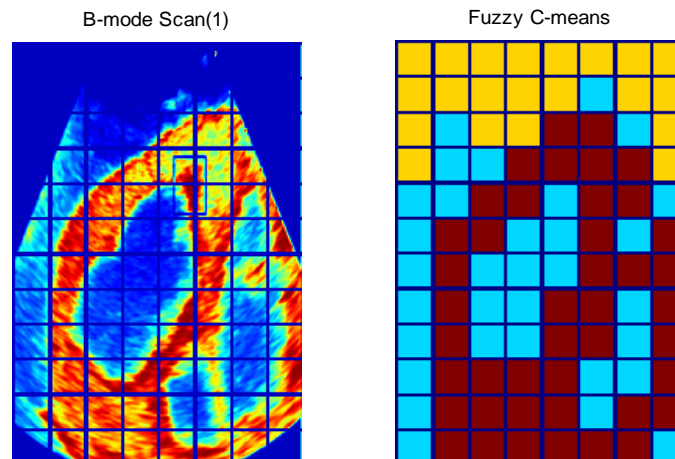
Results for heart ultrasound image with speckle detection results presented for Method 2 using Fuzzy C-means method. Light blue= FDS; Red=Non-FDS; Orange=Background.
